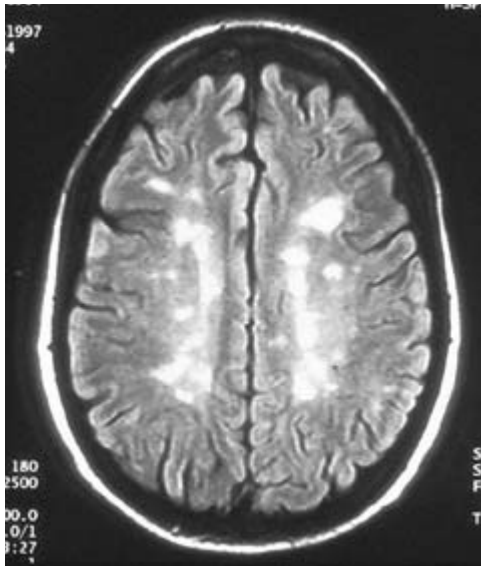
Fluid attenuation inversion recovery (FLAIR) sequence image of a transverse section from the brain of a patient with multiple sclerosis (MS). This image shows multiple high-signal periventricular and white-matter lesions. Although the FLAIR sequence is the most sensitive sequence for detecting MS lesions, it is not specific for demyelination.
